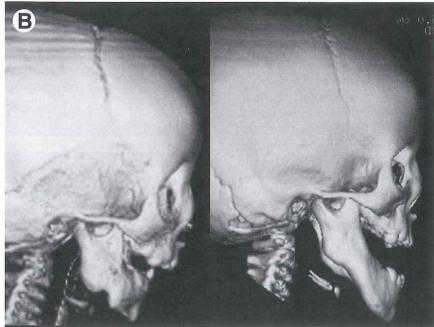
Preoperative (A) and 4-month postoperative (B) computed tomography scan comparisons. Note pin placement marks at mid-ramus and anterior body inferior border.
